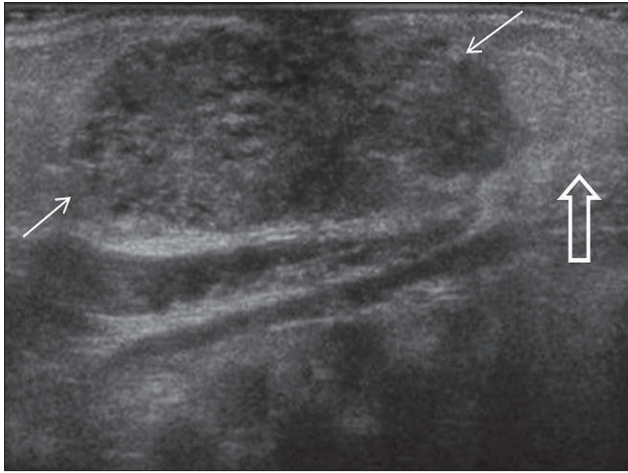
Ultrasound of left breast mass in radial plane shows a well-defined, oval, heterogeneously hypoechoic retroareolar mass (short arrows) with tiny cysts and hyperechogenicity of surrounding subcutaneous soft-tissues (open arrow)
